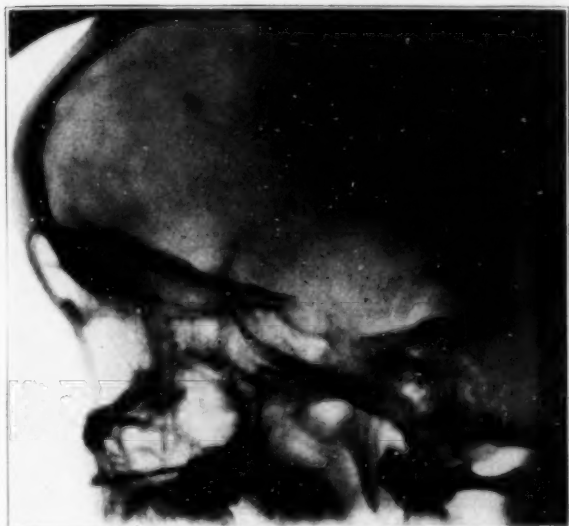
(case 4).—Roentgenogram, showing moderate atrophy of the dorsum sellae, complete disappearance of the posterior clinoid processes with no enlargement of the pituitary fossa; convoluted atrophy.
